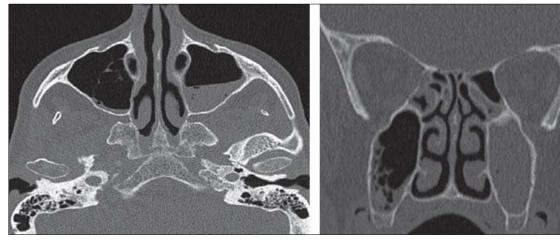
Axial slice (left) and coronal reconstruction (right) of a patient's sinus CT scan showing filling with a hydro-aeric level of the left maxillary sinus and gas bubbles in the maxillary sinus fluids, realizing a foamy appearance on the right consistent with bilateral acute maxillary sinusitis.
